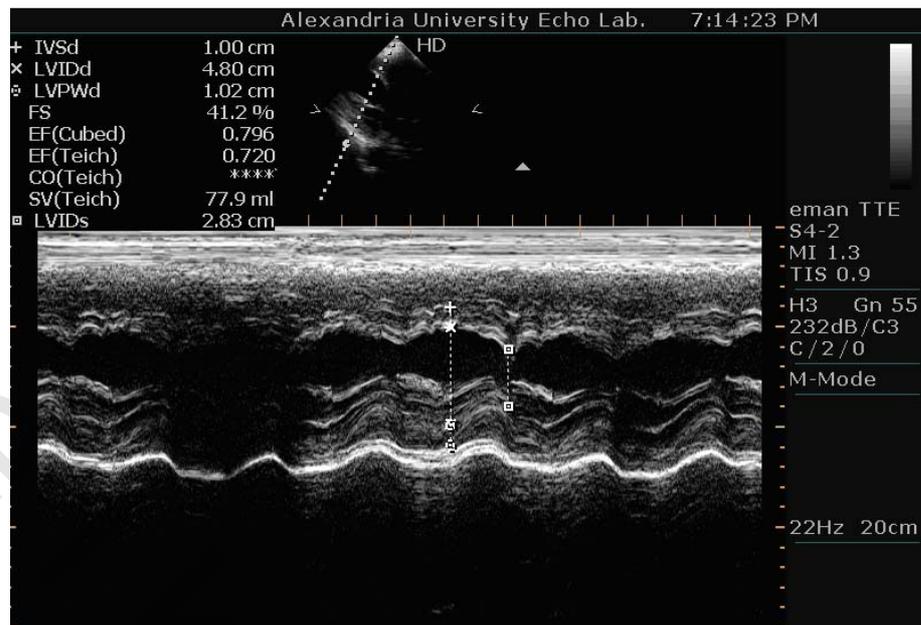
Conventional echocardiographic to assess EF after dialysis.
